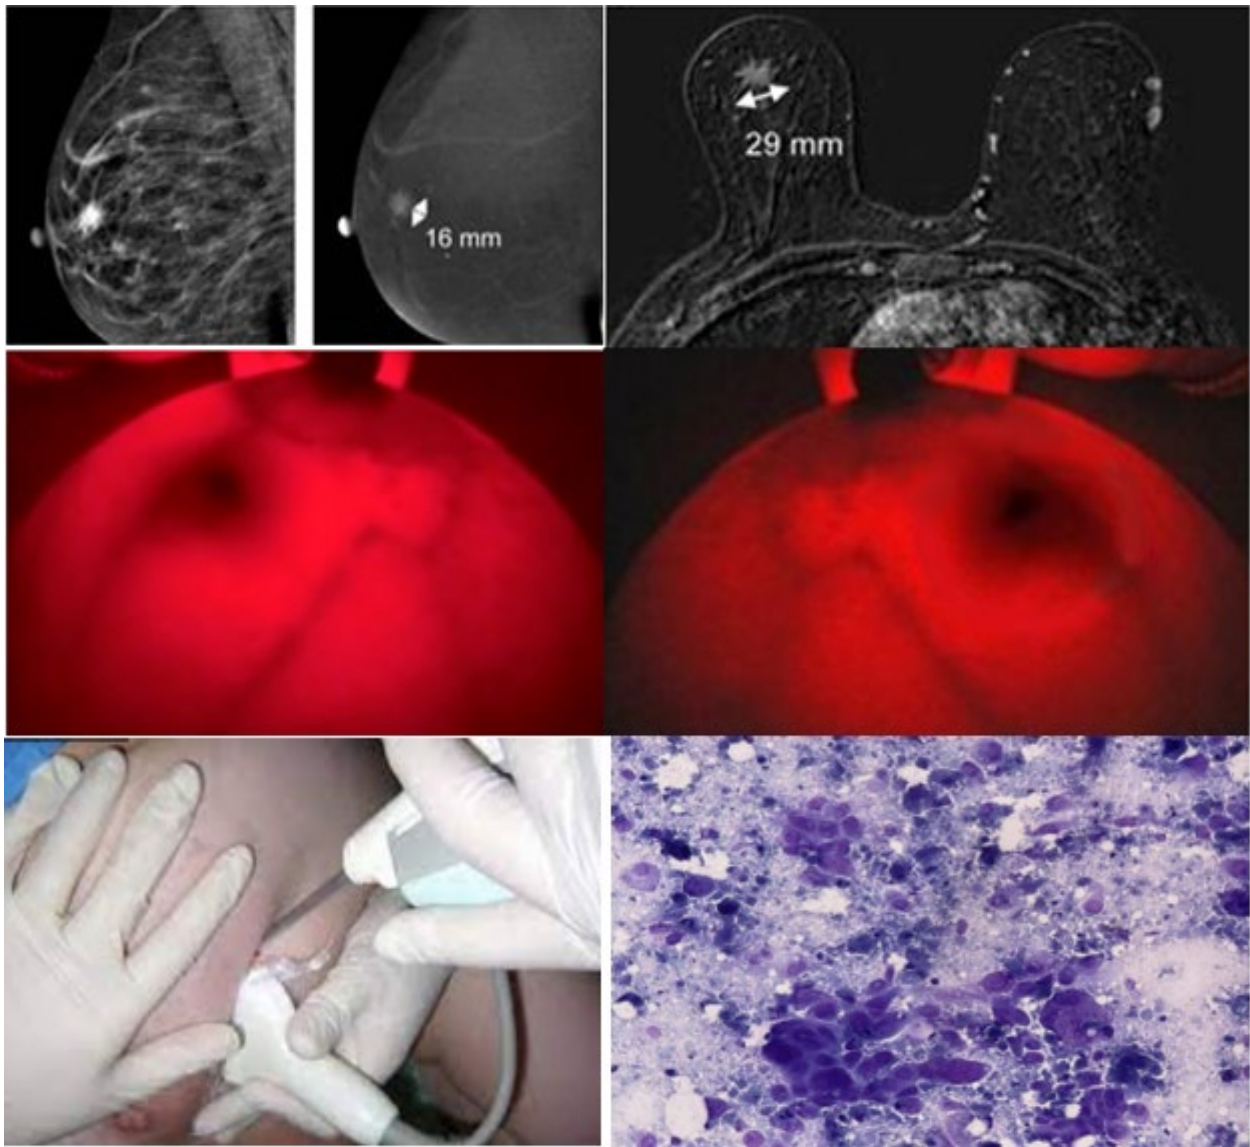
Images of MRI scans, BKA-06, and cell biopsies of breast cancer patient no. 7.
